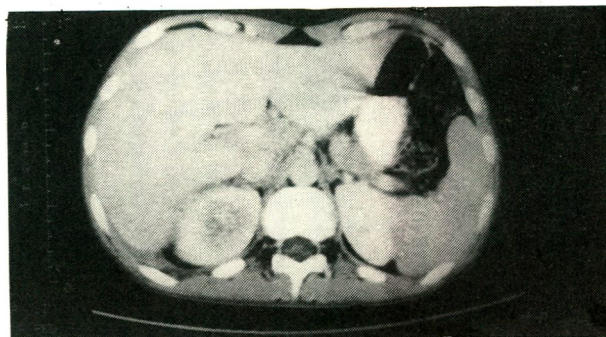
b. A lower CT scan cut showing the thickened upper pole of the right kidney and non-homogenous pattern.
